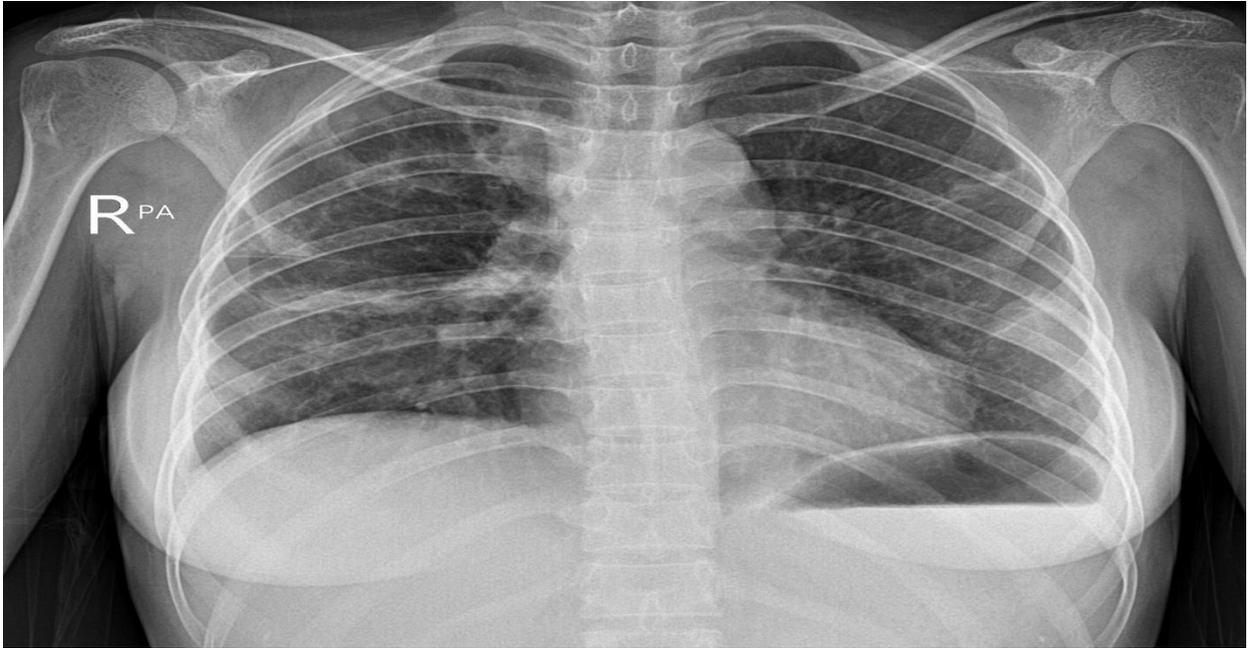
Posteroanterior (PA) chest radiograph at the 2-month follow-up.
